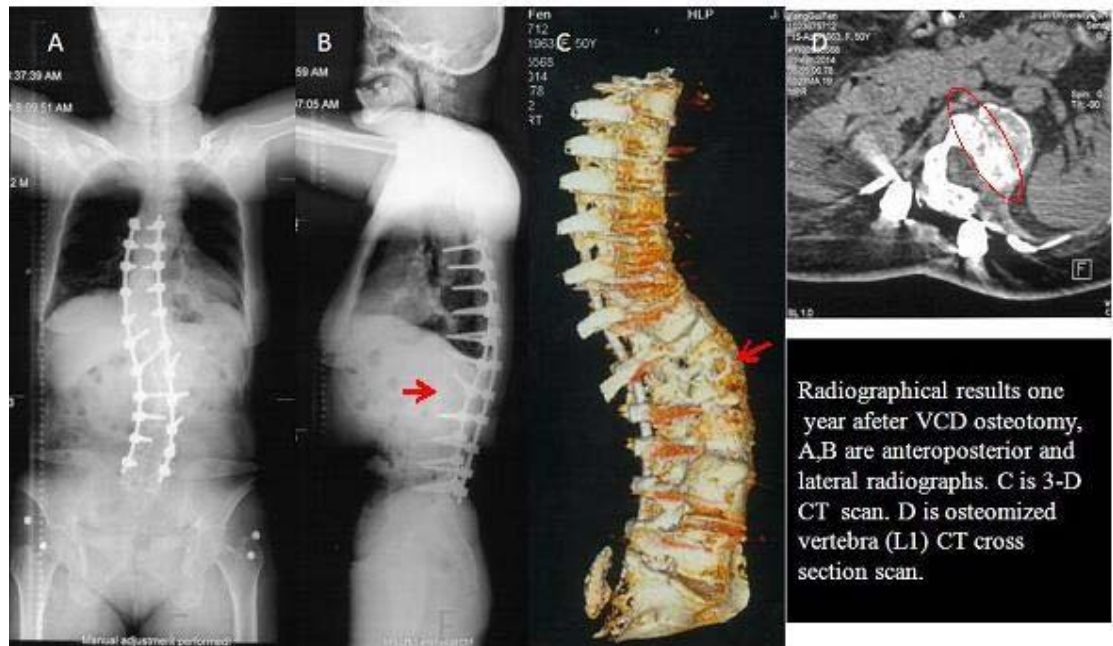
One year follow up radiographs and CTs of the 49 female patient underwent VCD osteotomy in Figure 4. Osteotomised segment was marked by red arrow in B and C, and bony healing area was observed in C which marked by red ring
